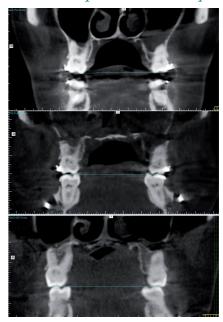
Patient 2. CT coronal views before surgery and 1 week and 3 year after surgery (top to bottom).
